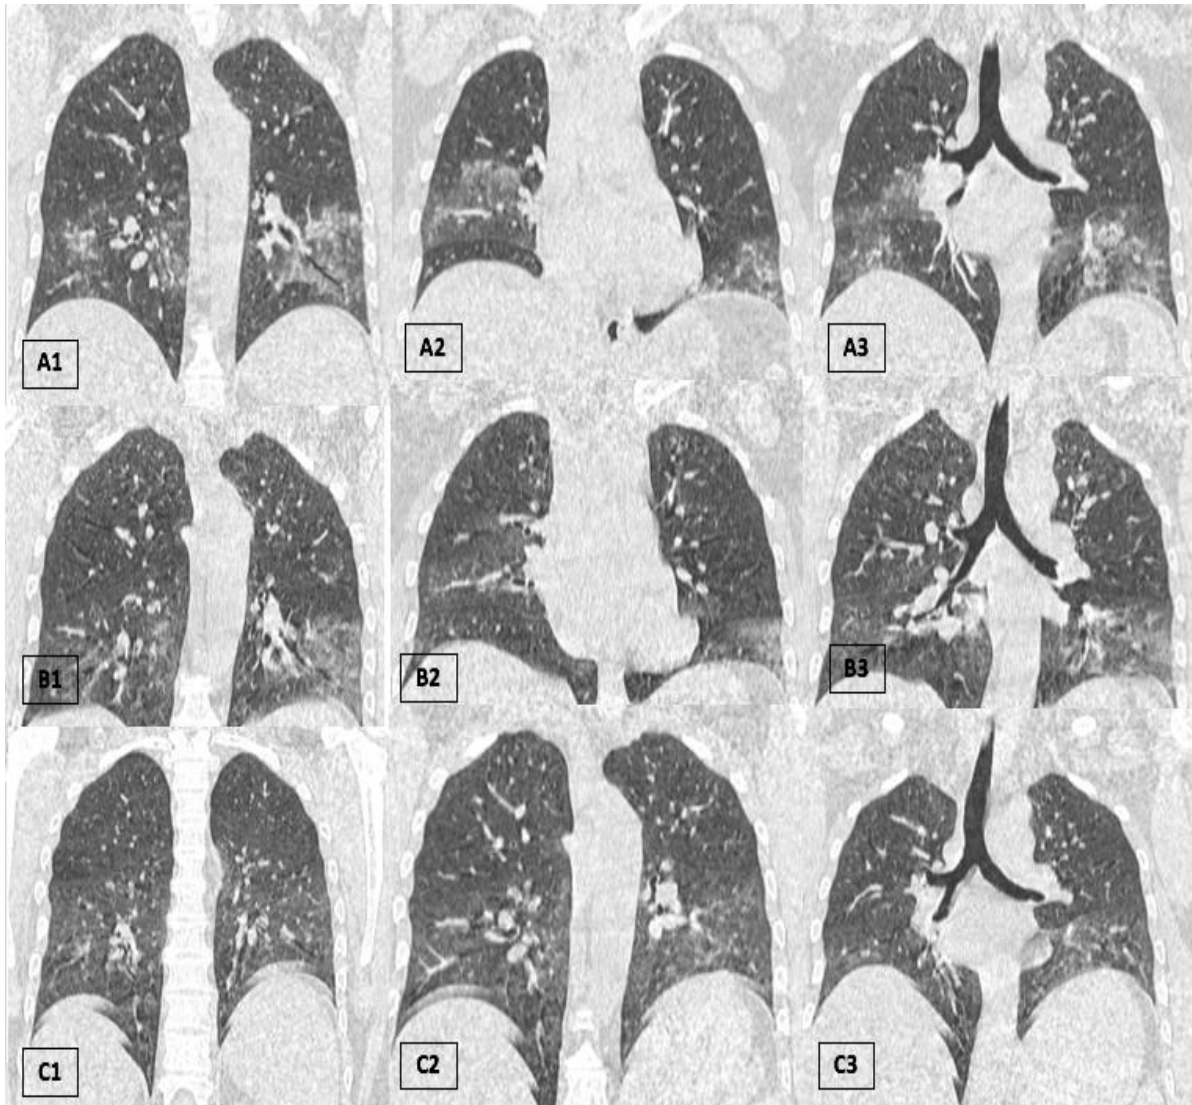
Coronal non-enhanced lung sequences chest computed tomography at presentation in (A1,A2,A3) and control CT respectively after 4 days in (B1,B2,B3) and after 10 days in (C1,C2,C3) , all images have the same window level and window width : (A1,A2,A3) Bilateral diffuse ground glass opacities interesting the inferior lobes and the superior right lobe associated to a small consolidation areas . (B1,B2,B3 & C1,C2,C3) : progressive disappearance of lung abnormalities.
